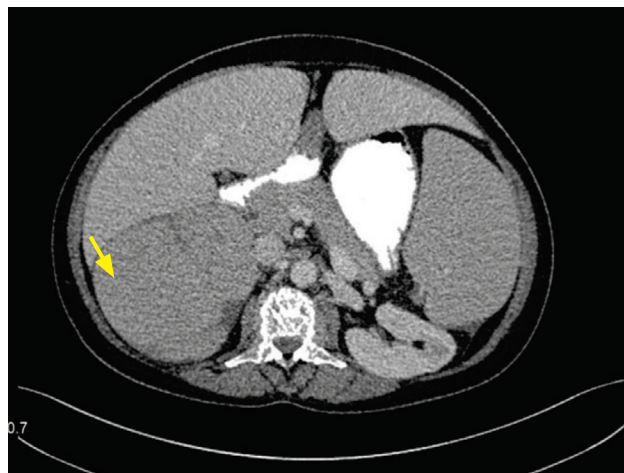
CT scan of the abdomen in 2018 showing large heterogenous enhancing right adrenal mass 11.0x9.8x14.8 cm (yellow arrow).
